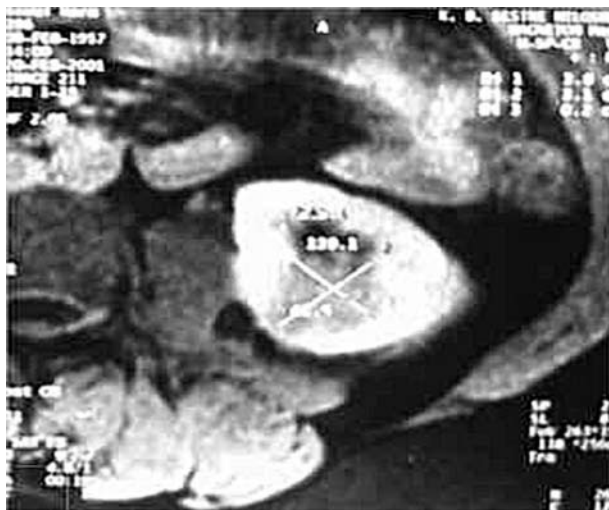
Postcontrast magnetic resonance image showing a homogeneous mass in the left kidney.
